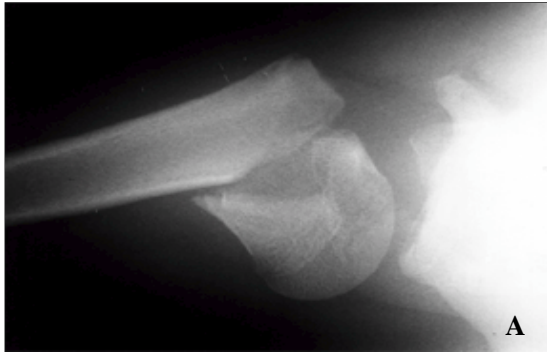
Preoperative radiograph of a two part fracture of the proximal humerus in a 20 years old male.
